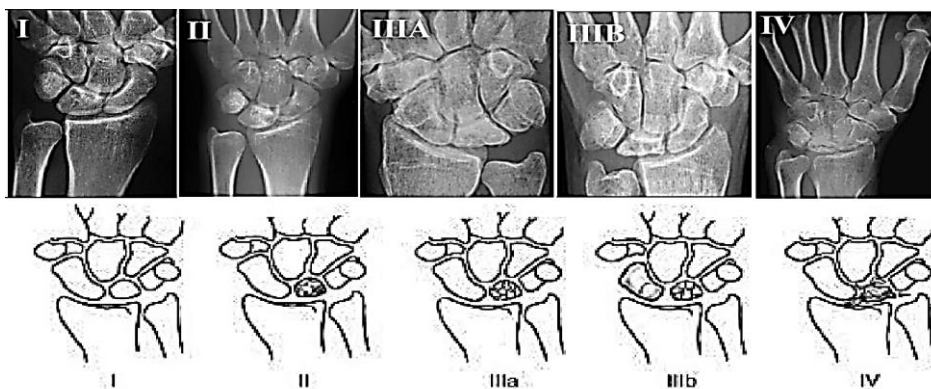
The Lichtman classification based on radiography, which was first described in 1977 by Lichtman et al. (6)
